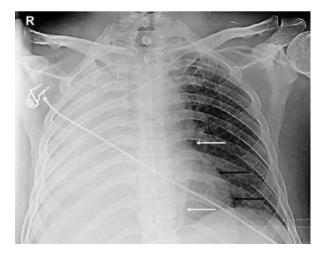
Chest radiograph frontal view in erect AP position showing complete "whiteout" of the right hemithorax. The right cardio-mediastinal silhouette and the right hemidiaphragm outline are not visualized (D.D.: pneumonia, lung collapse, and pleural effusion)
